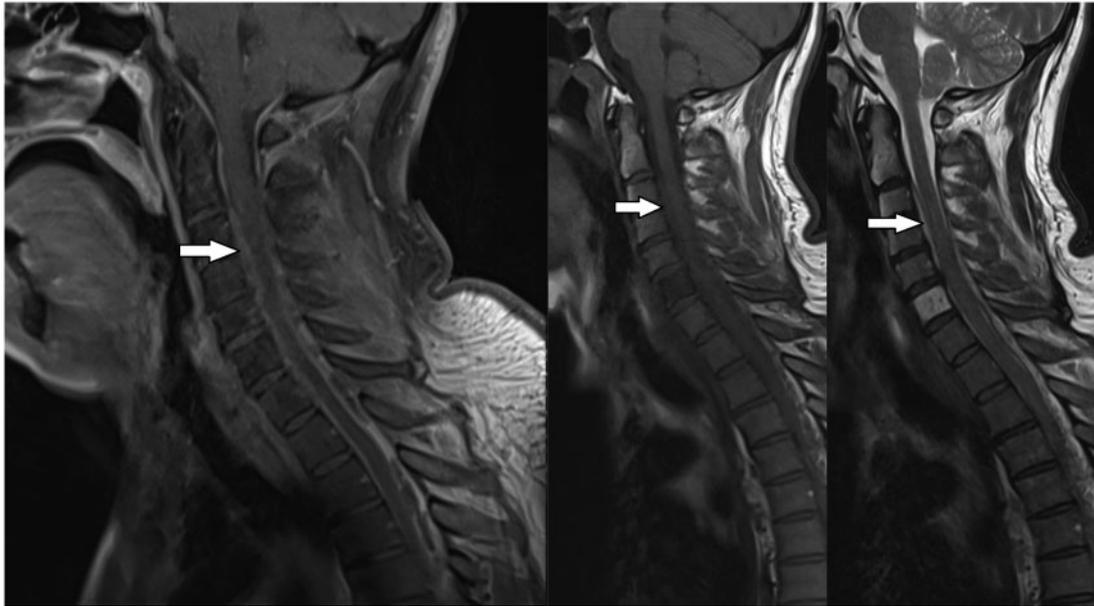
Magnetic resonance imaging spine images. From left to right: post-contrast T1, pre-contrast T1, and pre-contrast T2 (arrow demonstrating epidural abscess).
